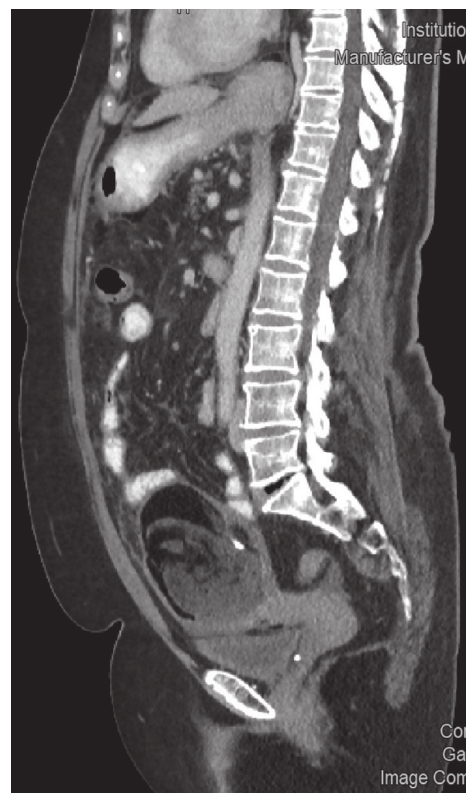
Sagittal contrast-enhanced computed tomography (CT) image showing a well-demarcated heterogeneous mass in the presacral region, containing fat, soft tissue, and calcified components-findings consistent with a sacrococcygeal mature teratoma.
